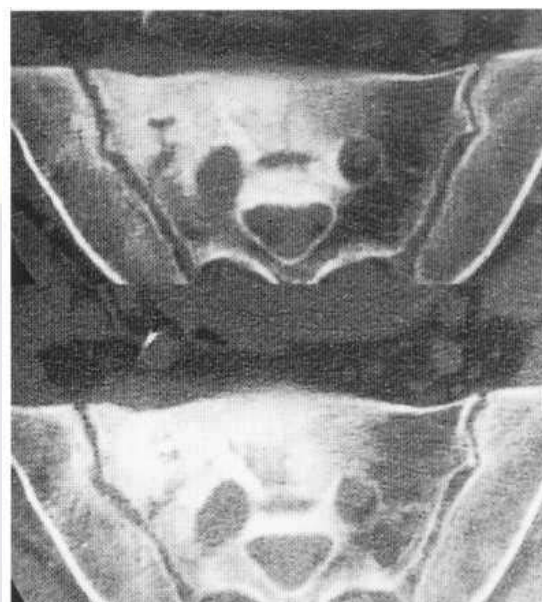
Metastasis CT. Sclerotic metastases involving the right side of the sacrum were shown by plain films but are seen more clearly by axial CT. This also shows bone destruction around the right sacral foramen and a vertical pathological fracture through the body of the sacrum.
